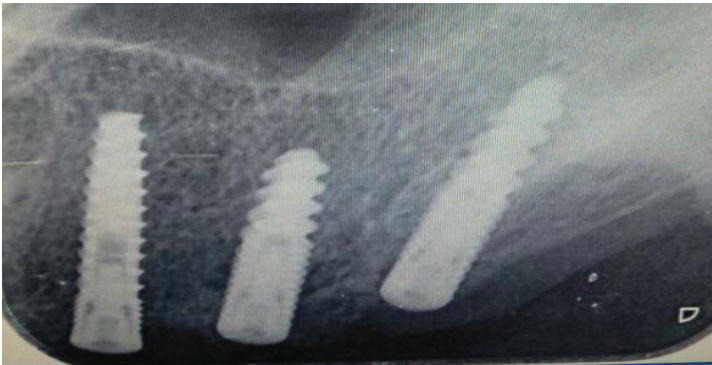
c) Radiograph showing Implant in Place
